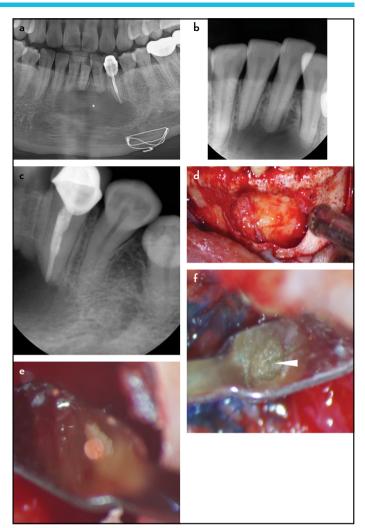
Diagnostic radiographs and clinical features of the surgical procedure. (a) Preoperative panoramic and (b, c) periapical radiographs showing a large periradicular lesion (asterisk). (d) Bony cavity after cyst enucleation. (e) The resected root surface. (f) The root-end cavity filled with mineral trioxide aggregate
